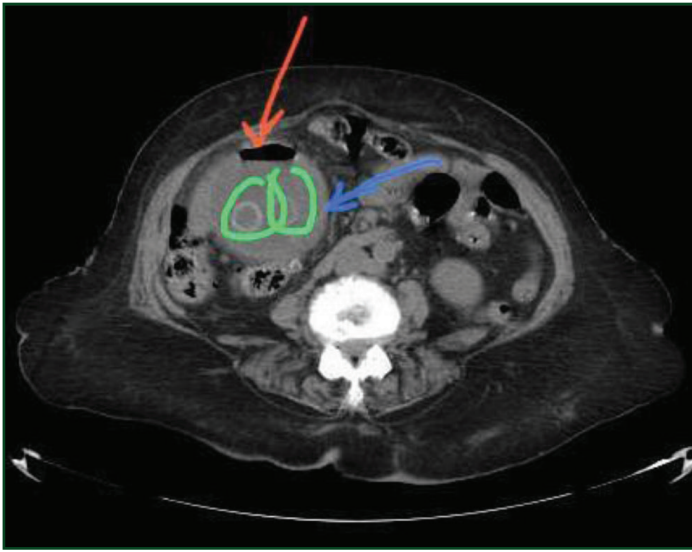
Non-contrast CT image showing orange arrow gas in GB lumen, green circle gall stones and blue arrows shows thicker GB wall.
